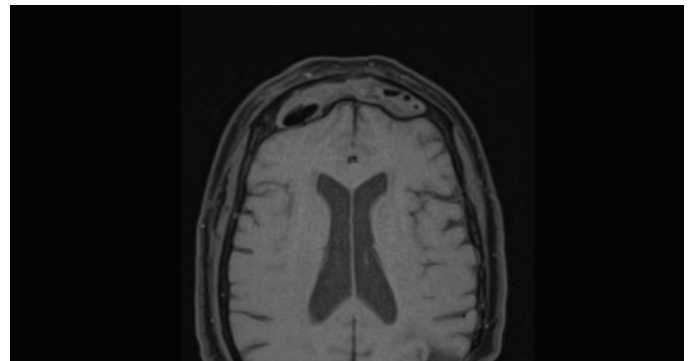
MRI T1 weighted imaging sequence showing a frontal sinus mass with a predominant hypointense sign
